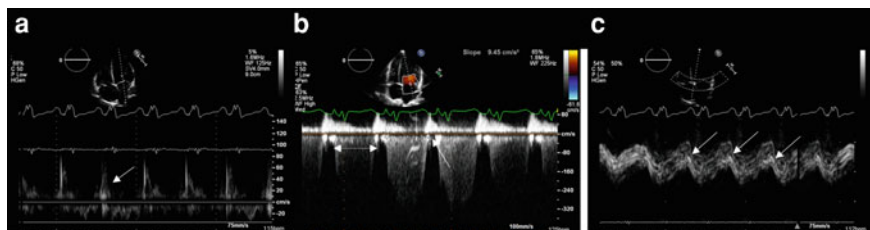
Long axis and Doppler diagnosis of ischaemia. Doppler and long-axis function demonstrating LV ischaemia in a patient with pulmonary oedema and globally impaired LV systolic function receiving ECMO. a transmittal PW Doppler showing the unexpected finding of isolated late (A wave) transmittal filling. b CW Doppler of MR of 400 ms duration (dotted arrow). This prolonged duration of systole allows very little time for transmittal filling (solid arrow), explaining the absence of early diastolic filling in A. c M-mode of the long axis of the septum (apical 4-chamber view) demonstrating prolonged and reduced excursion, with post-ejection shortening (arrowed). This prolongation of systole in the long axis means the LV is generating tension into early diastole, and therefore MR is prolonged and early transmittal filling is suppressed. The reduction in long axis excursion in this patient and poor quality of transthoracic images, and the partial bypass from ECMO meant standard regional wall motion scoring and the TDI were uninterpretable. The patient underwent coronary angiography with subsequent revascularisation. LV; left ventricle, ECMO; extracorporeal membrane oxygenation, PW; pulse wave, CW; continuous wave, MR; mitral regurgitation, TDI; tissue Doppler imaging
